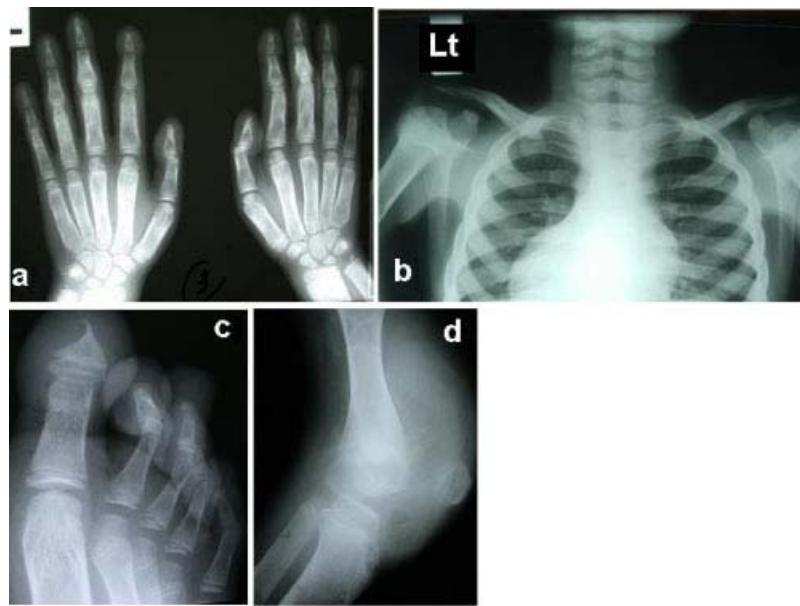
(a) Radiograph showing narrow proximal interphalangeal spaces of digits 2–4. Acro-osteolysis of distal phalanges. (b) Radiograph showing hyperostotic thoracic cage with broad ribs. The lateral portions of both clavicles are hypoplastic. Cardiomegaly is noted. (c) Severe acro-osteolysis of toes. (d) Expanded metaphyses of the distal femur, proximal tibia, and fibula. The patella is unremarkable.
